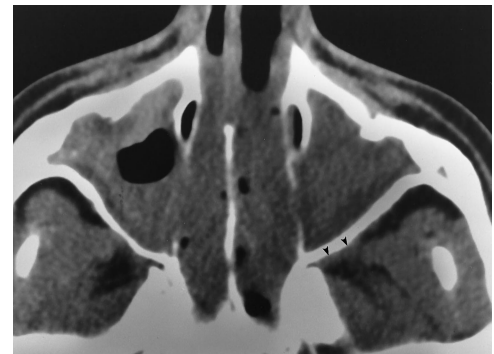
Noncontrast CT scan shows a single instance of soft-tissue attenuation material in the left retroantral fat plane (*arrowheads*) that could mimic soft-tissue infiltration.
